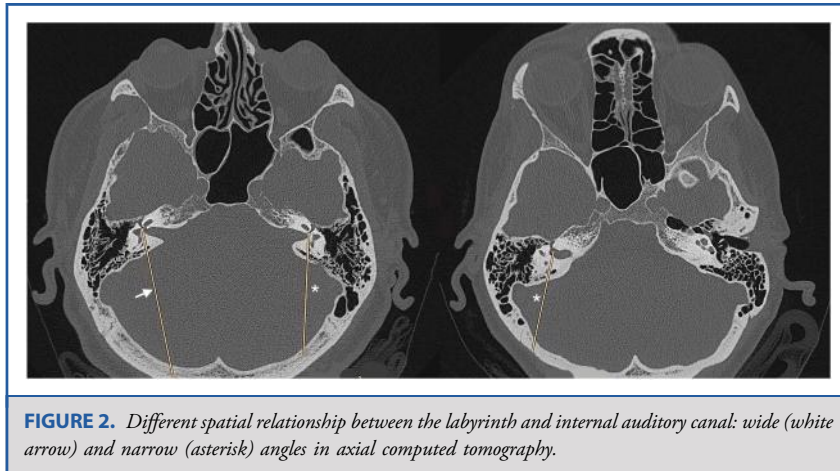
Different spatial relationship between the labyrinth and internal auditory canal: wide (white arrow) and narrow (asterisk) angles in axial computed tomography.
